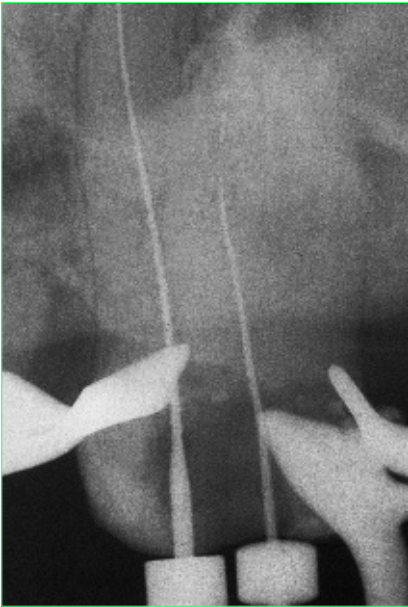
The radiograph suggested calcification of the root canal systems, which were no longer visible in the film. Nevertheless, clinical assessment revealed two root canal systems.
